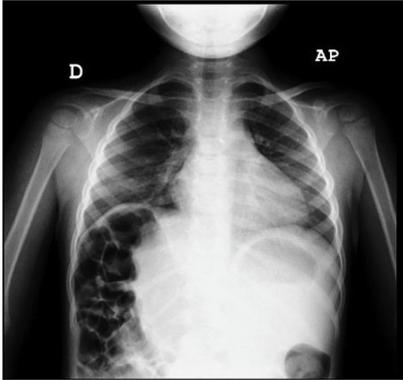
Posteroanterior chest radiograph. Visualization of the bowel loops interposed between the diaphragm and liver, which is displaced toward the midline. No features of consolidation.
